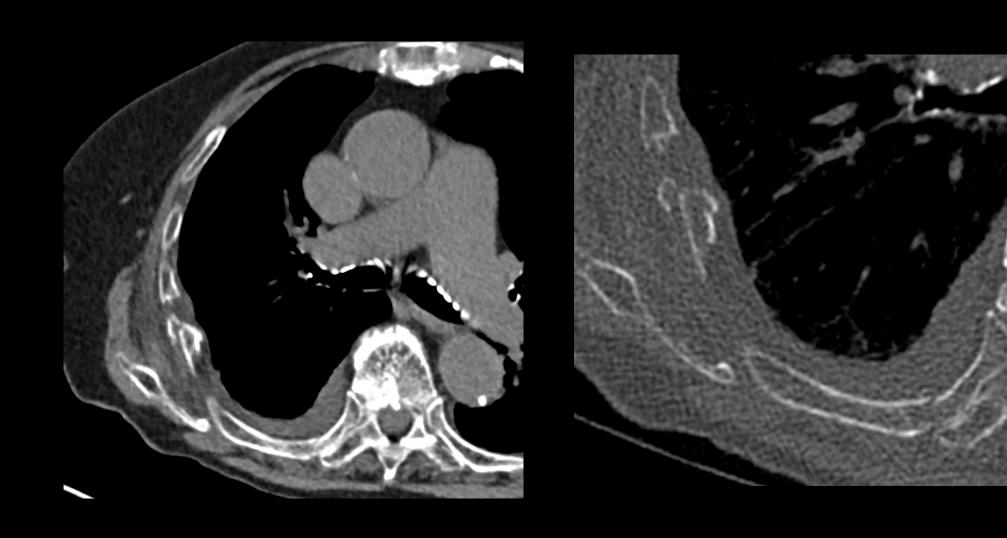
Avial image pon-contrast enhanced CT of the chest. Anterior ribs (red)
